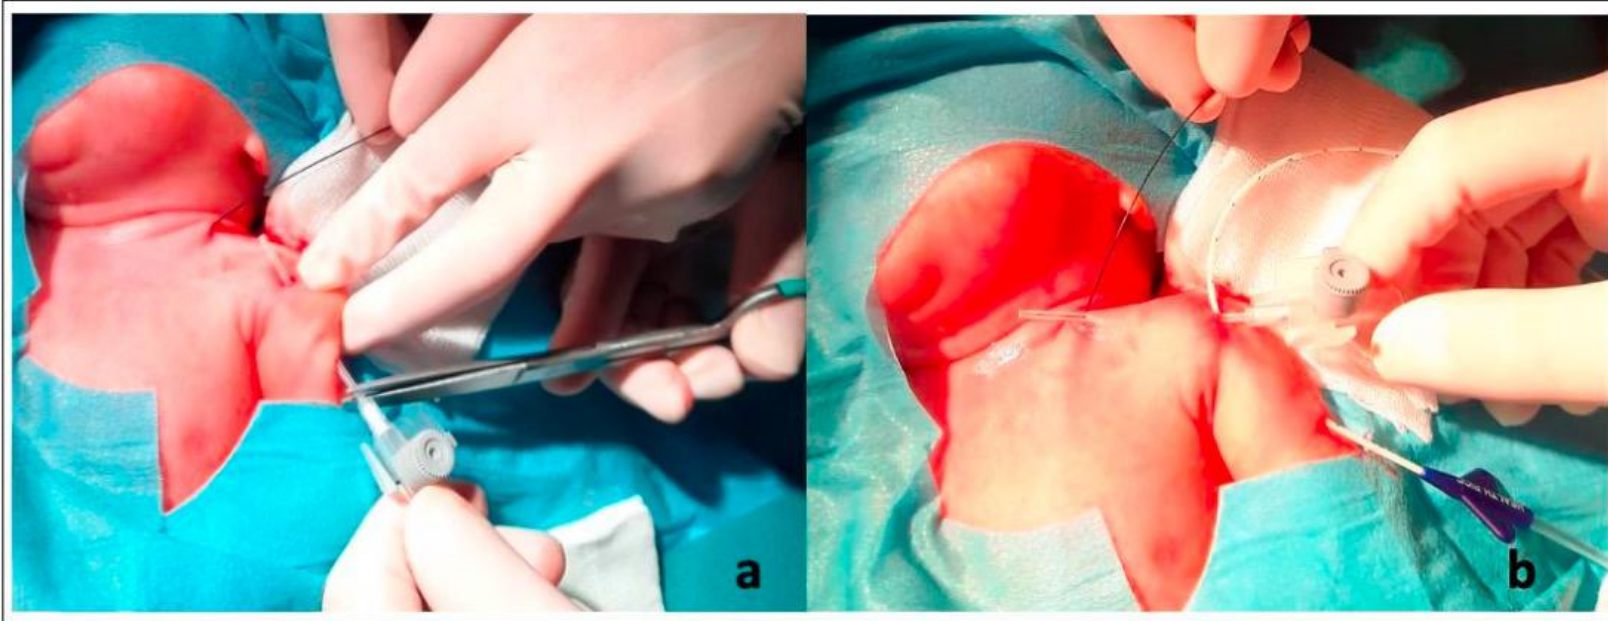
Double tunnel technique to CTA-tunneling. CTA tunnel is prepared by hydro-dissection with saline using two 16G cannulas. a. first tunnel, from mid-arm to shoulder using a 16G cannula passes in the subcutaneous tissue from the planned exit site to shoulder; it is necessary to cut off the end of the cannula with the stabilizing wings, then the catheter is introduced inside the cannula and once the catheter has gone through, the cannula must be removed; b. the second tunnel, from shoulder to supraclavicular venipuncture point using a second 16G cannula, the procedure for passing the catheter through the cannula is identical to that done with the first tunnel.
